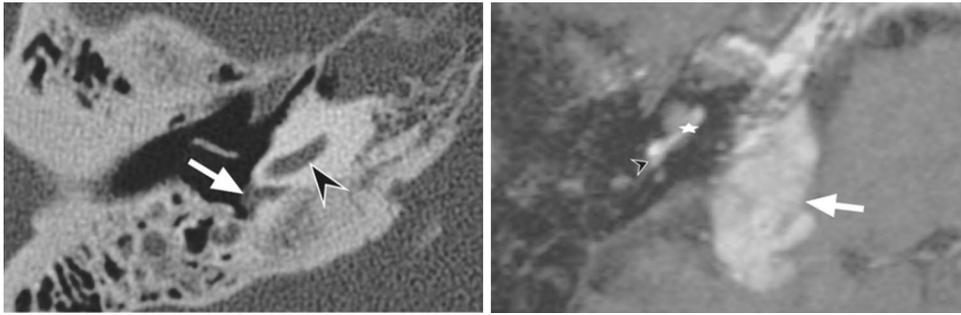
Case 2, pathologically-proven vestibular schwannoma extending towards the middle ear through the inner ear. a Axial non-enhanced temporal bone CT showing a hypodense nodule at the level of the round window (arrow). On CT the cochlea (arrow head) and the rest of the tympanic cavity appeared normal. b Axial T1-weighted contrast-enhanced spin-echo sequence acquired at 3 T, 10 min after
